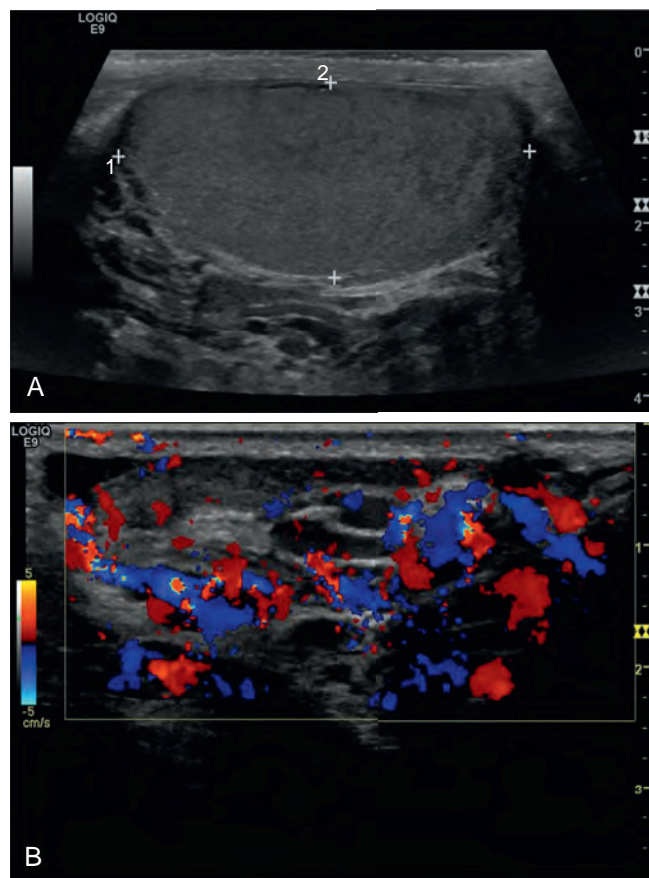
Color duplex Doppler ultrasonography of scrotum demonstrating varicocele. Dilated veins adjacent to the testis are exhibited in A, and directional flow in the vessels is revealed in B.
